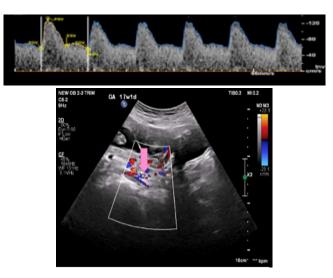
Uterine artery doppler, measuring the PI
